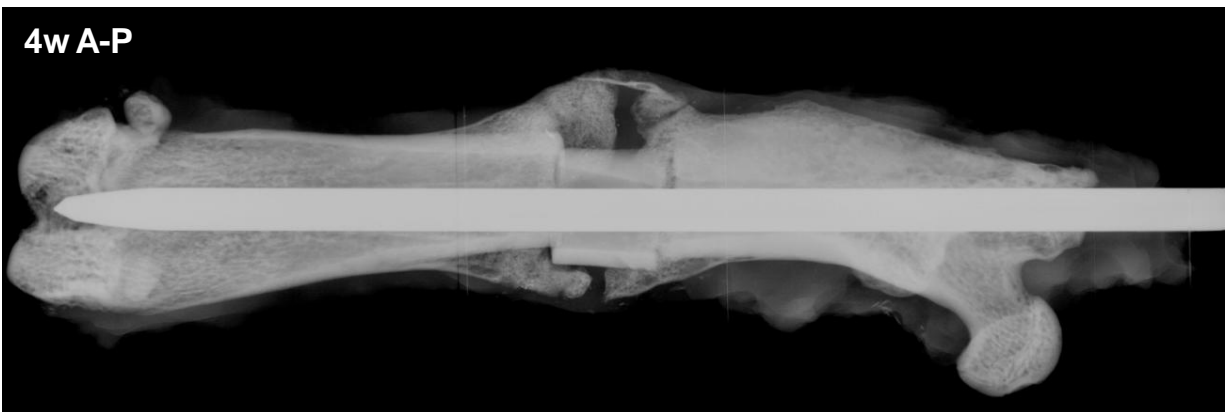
Representative radiographical images for 4 week time point. (cont.)
